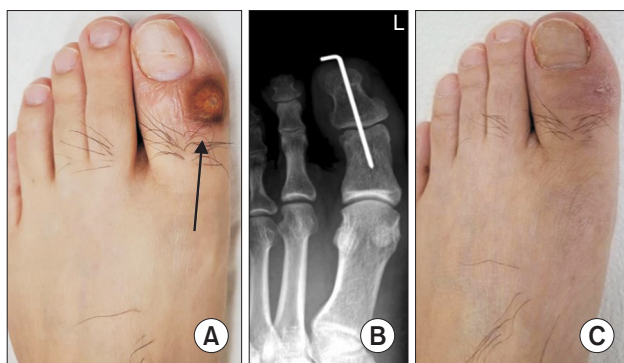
(A) Recurrent ganglion cyst with discharge of the first toe after two previous excisions (black arrow). (B) Postoperative follow-up X-ray. (C) Healed without recurrence of ganglion at 15-month follow-up.
